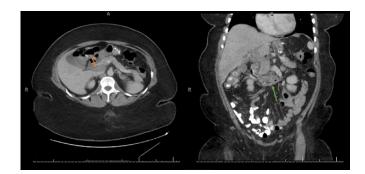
Axial and Coronal CT abdomen/pelvis with oral & intravenous contrast showing hypoattenuation of the main portal vein (orange arrow), intrahepatic portal veins, and involvement of the superior mesenteric vein (green arrow).
